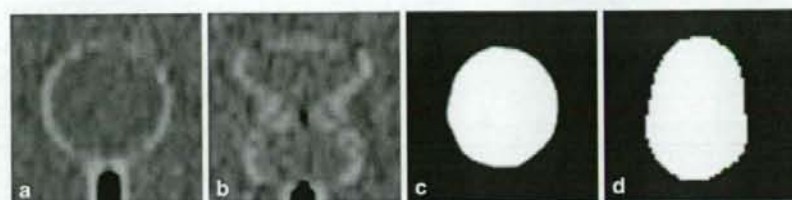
Digitally reconstructed radiographs (DRRs) of a 28-mm-diameter sphere generated from computed tomographic (CT) images and positron emission tomographic (PET) images in a sagittal plane. The total translation in the moving experiment was 20 mm. a, b DRRs of CT images generated from static and moving
